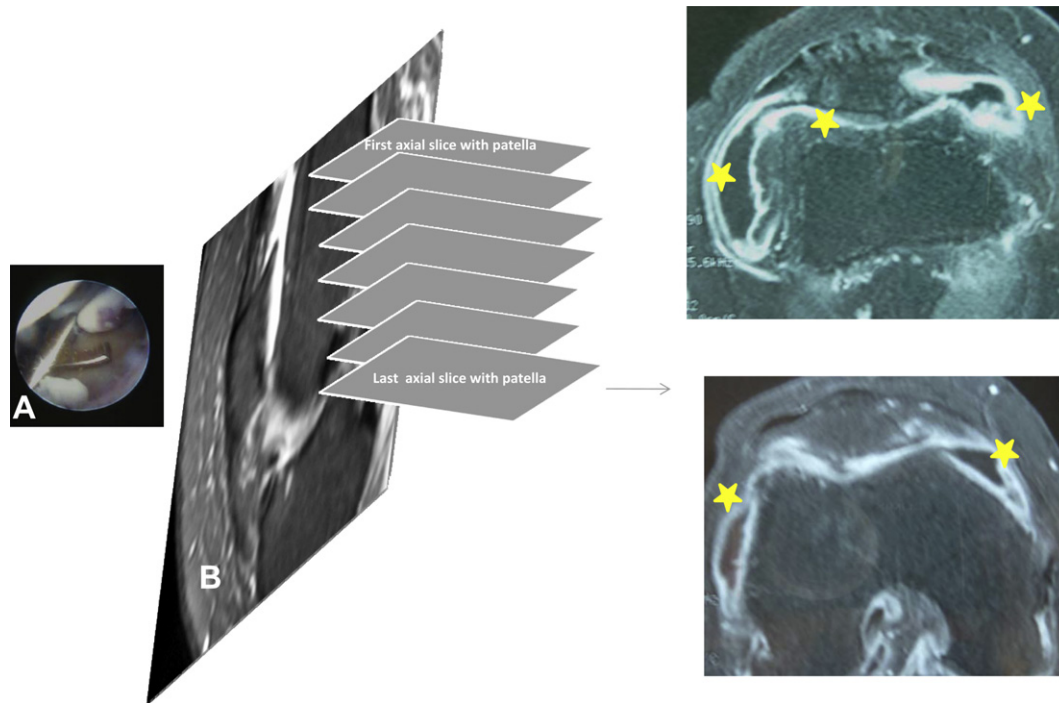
Synovial biopsies samples were performed during arthroscopy (A) in five sites of interest (three in the suprapatellar recess (lateral central and medial parts) performed just above or laterally to the upper part of the patella and two in the lateral and medial femoral gutters near the inferior part of the patella. MRI-synovitis score assessed synovitis on the same five sites of interest. On the first and the last axial slides where patella is still visible enhanced synovitis is scored according to its degree of thickening (yellow arrow) (C).
